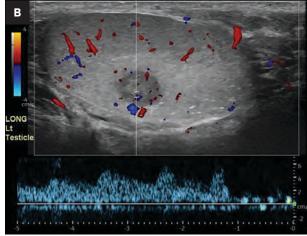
(A) Longitudinal US of the left testis shows microlithiasis and a hypoechoic mass measuring 1.0 x 0.7 cm (calipers). (B) Longitudinal Doppler US of the left testis shows flow in the solid mass.
